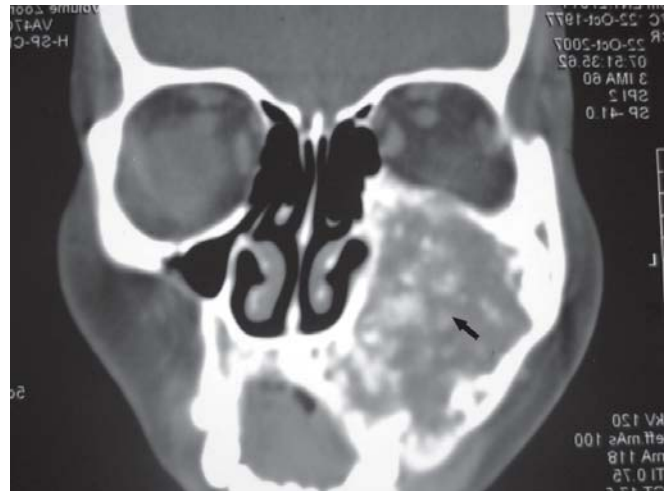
CT scan (coronal section) showing mixed radiolucency of left maxilla displacing orbital floor—monostotic fibrous dysplasia
